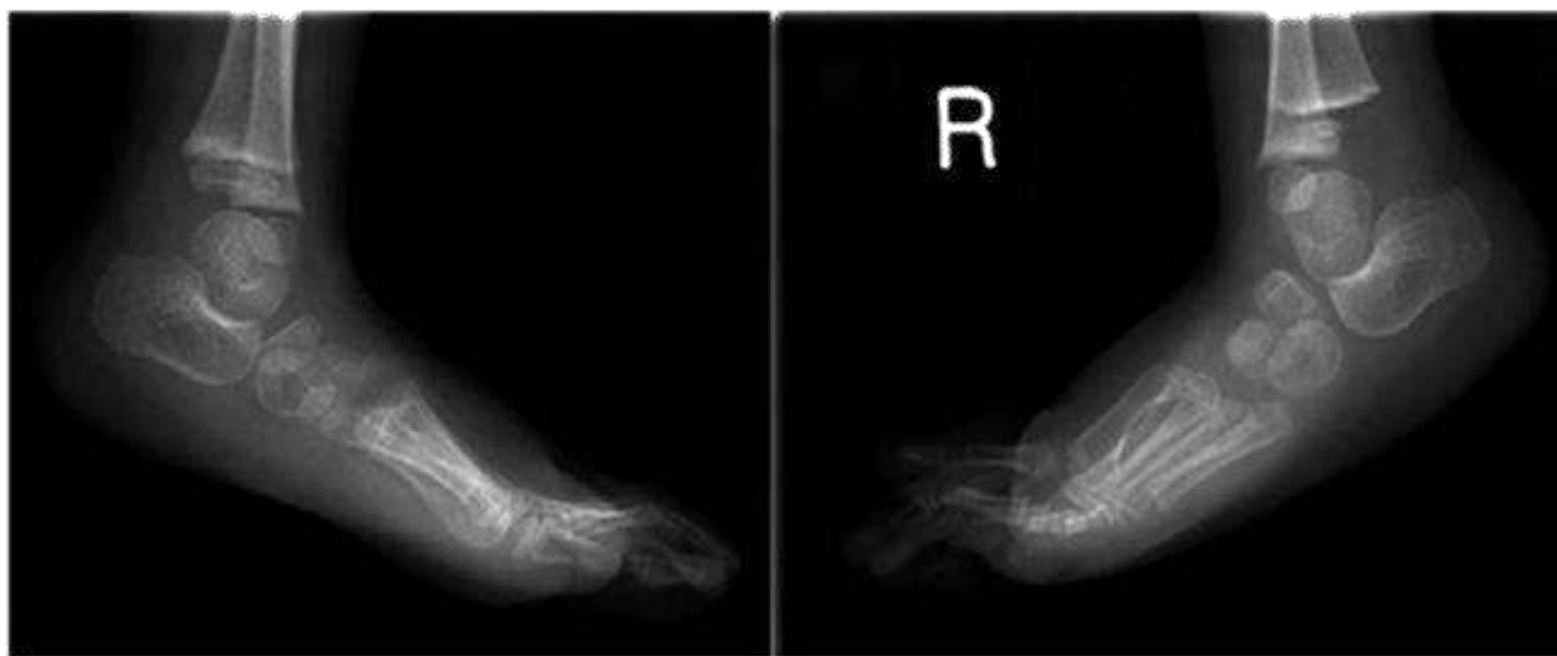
Plantar flexion lateral foot and ankle X-rays of a child with foot deformity.
